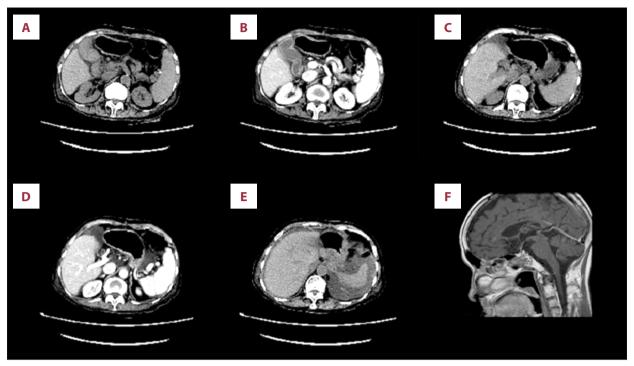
Computerized tomography images indicated normal adrenal glands (A–D) and ascites (E), and magnetic resonance imaging indicated a normal pituitary (F). (A) Plain abdominal computerized tomography (CT) scan; (B) The arterial phase; (C) Plain CT scan; (D) The arterial phase; (E) Plain CT scan; (F) T1 plain MRI scan of the pituitary gland.
